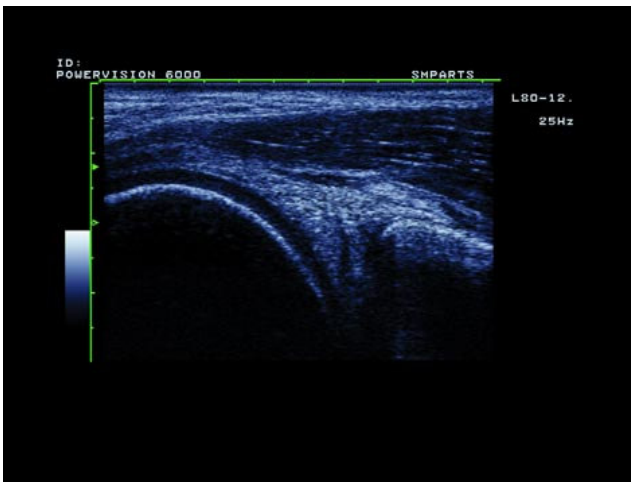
The B-color palette is used to increase the contrast, which emphasizes the meniscal tear. (Clinical Image made on the PowerVision 6000 Ultrasound System and courtesy of Toshiba Medical Systems Europe. Permission from Toshiba Medical Systems Europe)
